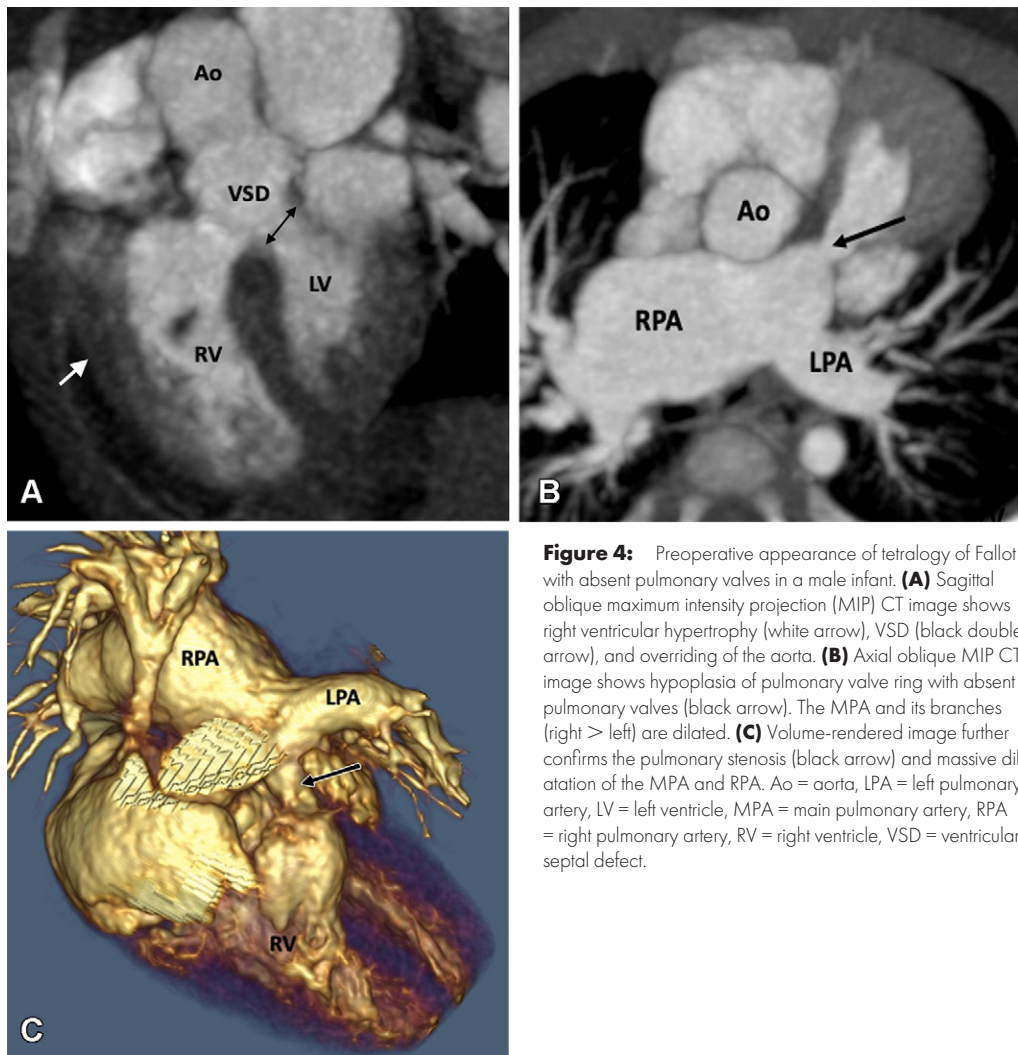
Preoperative appearance of tetralogy of Fallot with absent pulmonary valves in a male infant. (A) Sagittal oblique maximum intensity projection (MIP) CT image shows right ventricular hypertrophy (white arrow), VSD (black double arrow), and overriding of the aorta. (B) Axial oblique MIP CT image shows hypoplasia of pulmonary valve ring with absent pulmonary valves (black arrow). The MPA and its branches (right > left) are dilated. (C) Volume-rendered image further confirms the pulmonary stenosis (black arrow) and massive dilatation of the MPA and RPA. Ao = aorta, LPA = left pulmonary artery, RPA = right pulmonary artery, LV = left ventricle, MPA = main pulmonary artery, RV = right ventricle, VSD = ventricular septal defect.
